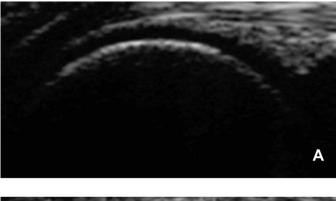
Musculoskeletal ultrasound images. A, Normal cartilage on anterior capitellum (hypoechoic band). B, Chondral lesion on anterior capitellum (arrow).
